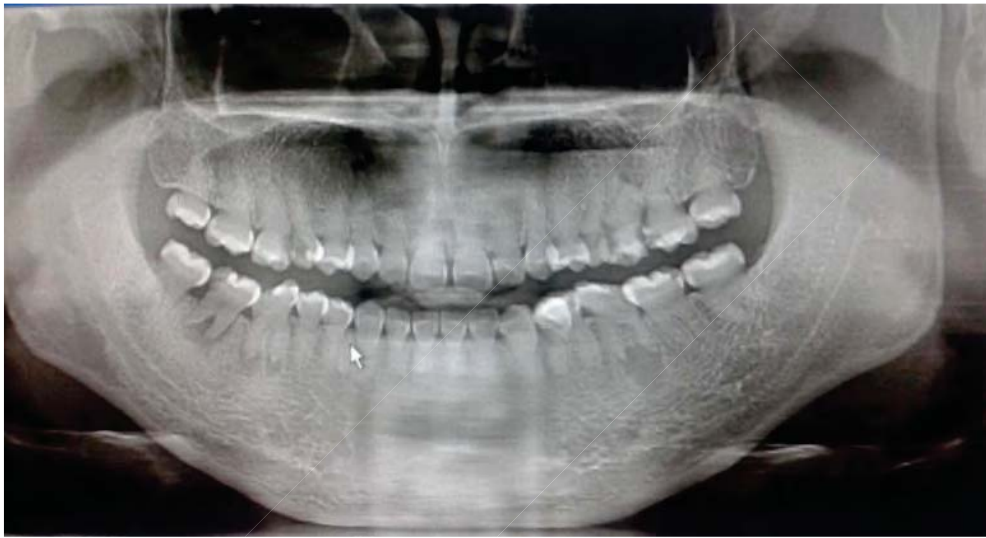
OPG showing missing pulp chambers with complete Root obliteration of canals. Multiple periapical radiolucencies are also seen.
